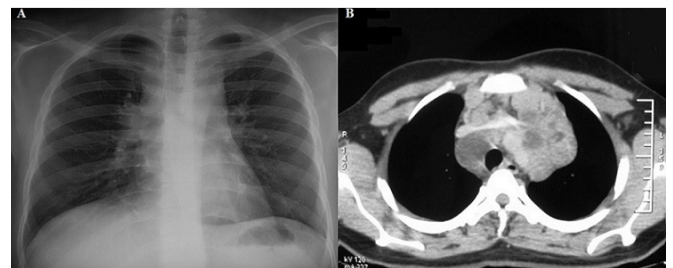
(A) a chest radiography showing an enlarged mediastinum; (B) a thoracic CT showing a large and inhomogeneous mass in the mediastinum
